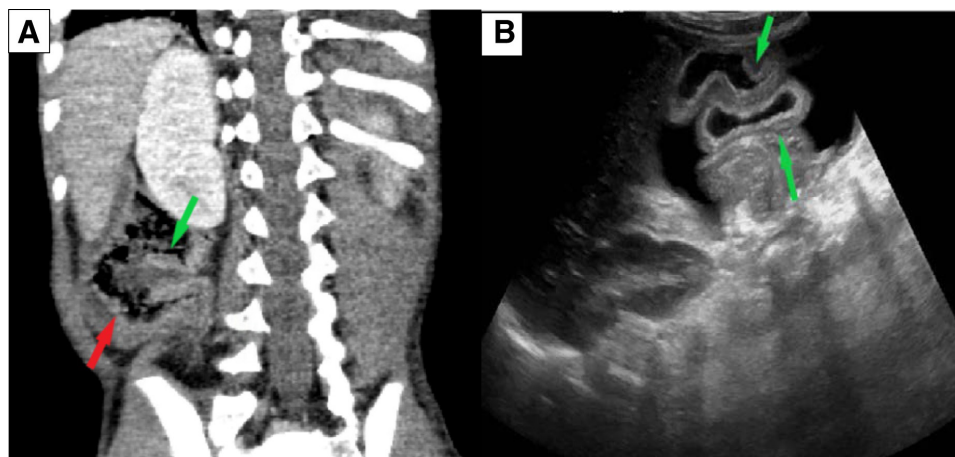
A, CT abdomen showing normal ileum (green arrow) and cecum (red arrow). B, Ultrasound abdomen showing small bowel wall thickening (green arrow).
